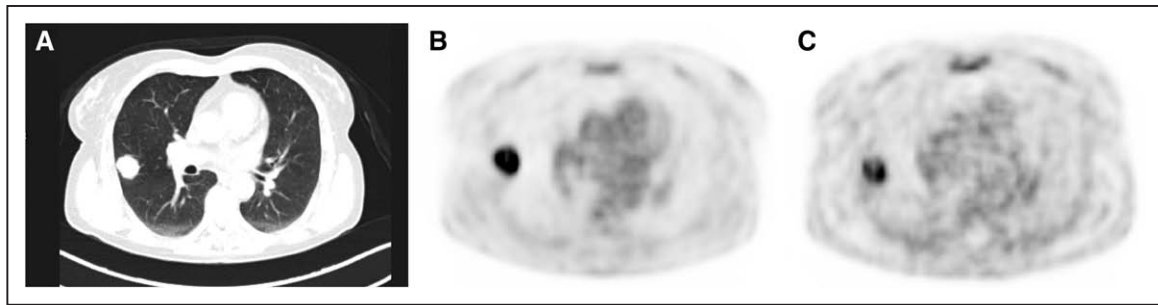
Display of representative axial slices of computed tomography ([CT], A) and [^{18}F]FDG- (B) and CXCR4 (C)-directed positron emission tomography (PET). All modalities present a pulmonary lesion in the right upper lobe, highly consistent with lung cancer. CXCR indicates CXC-motif chemokine receptor.
